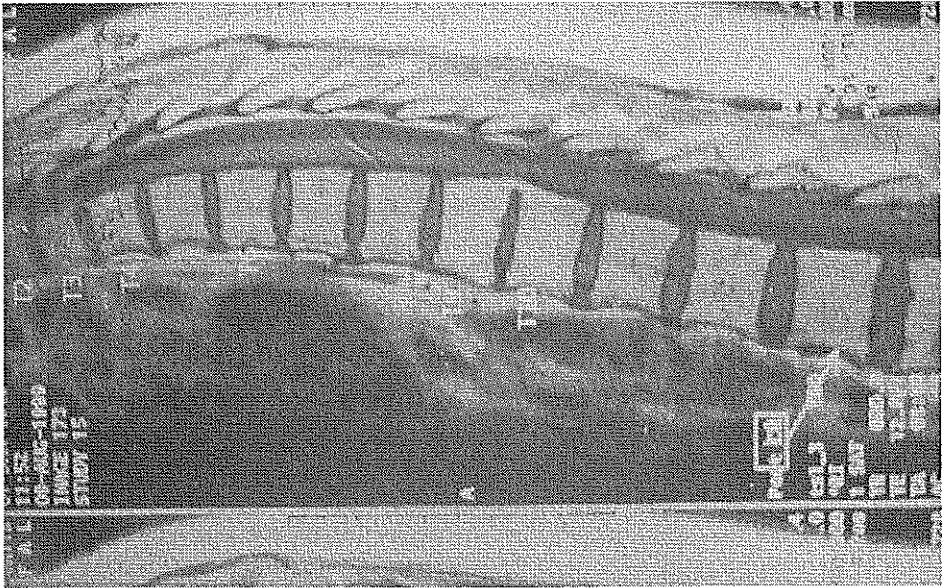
MRI is showing a thoracal epidural abscess hypointense on T 10 weighted.
